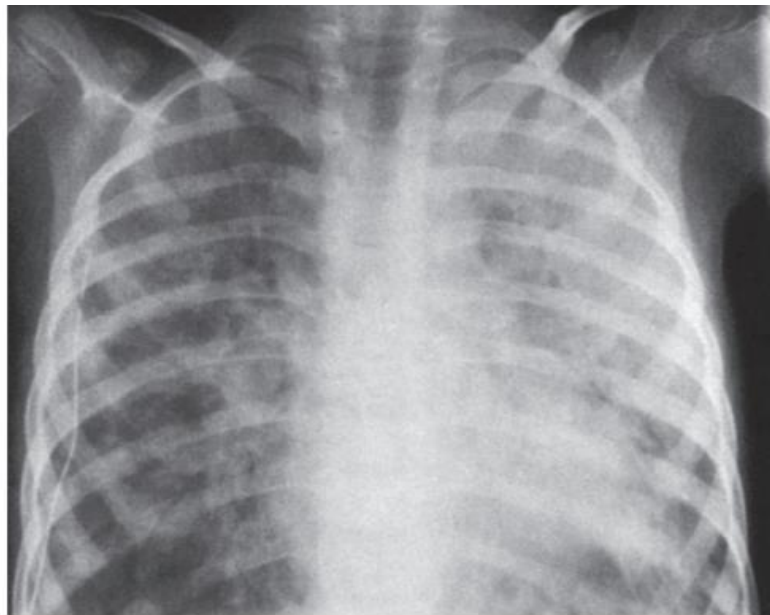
Chest radiograph showing bilateral interstitial and alveolar infiltrates in a child with acute lymphocytic leukemia and *Pneumocystis* pneumonia.
